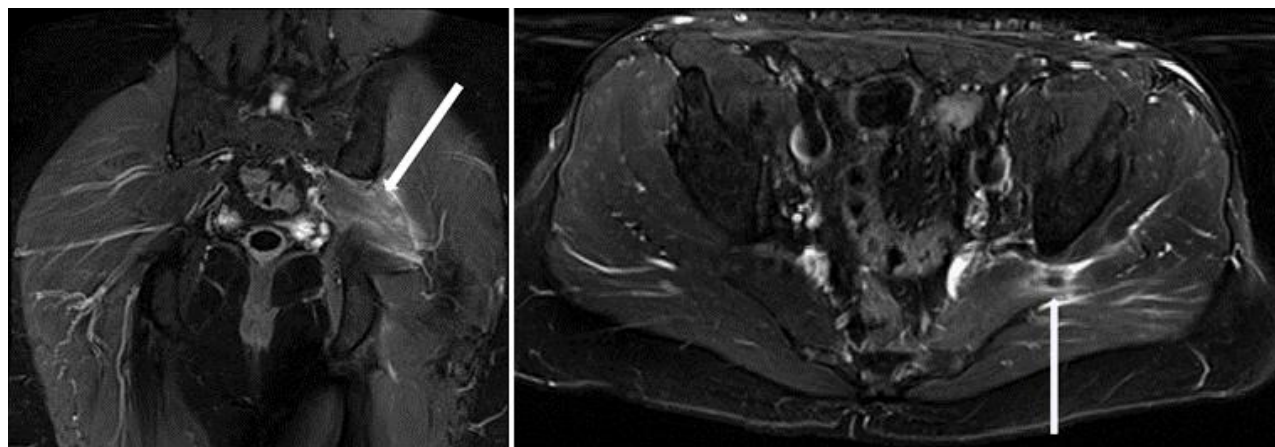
MRI images in 42-year-old male with sarcoidosis. Left image: Coronal STIR pelvis MRI. The left piriformis muscle is diffusely oedematous and swollen. Right image: Axial STIR pelvis MRI. There is a low-signal deposit within the left piriformis muscle with surrounding muscle oedema.
